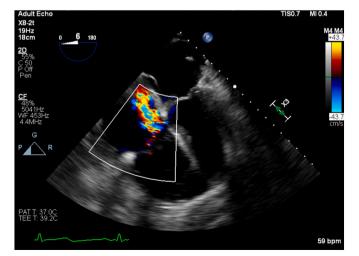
Midesophageal 4-chamber color Doppler TEE view demonstrating severe tricuspid regurgitation.
